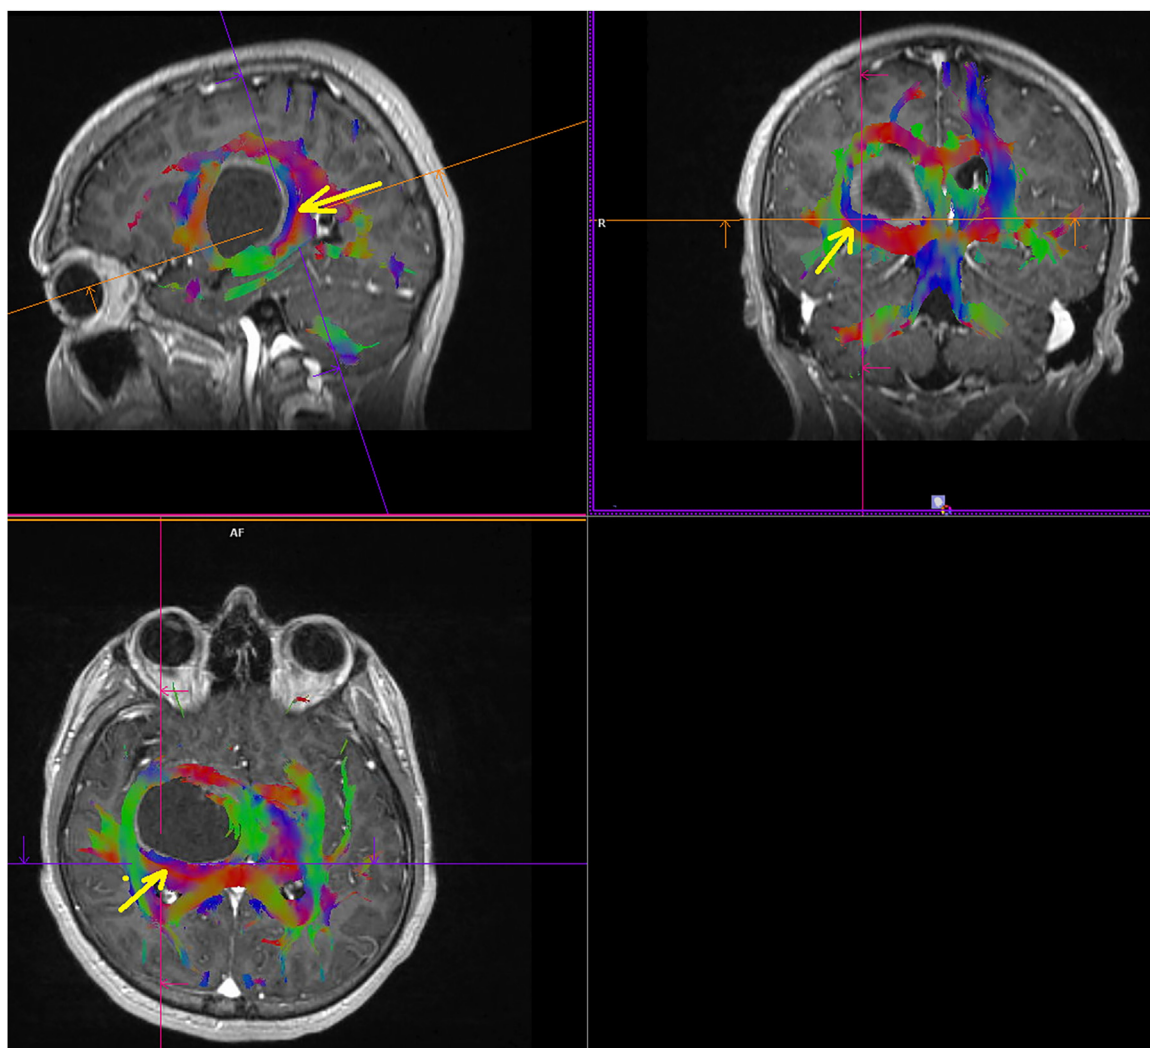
Magnetic resonance images of a patient with a large right-sided tumor in the thalamus and in the mesencephalic peduncle. The sagittal and axial scans show that the internal capsule is located posteriorly from the tumor. The transinsular approach through the lenticular nucleus was adopted with the intention to spare the internal capsule (yellow arrow).
